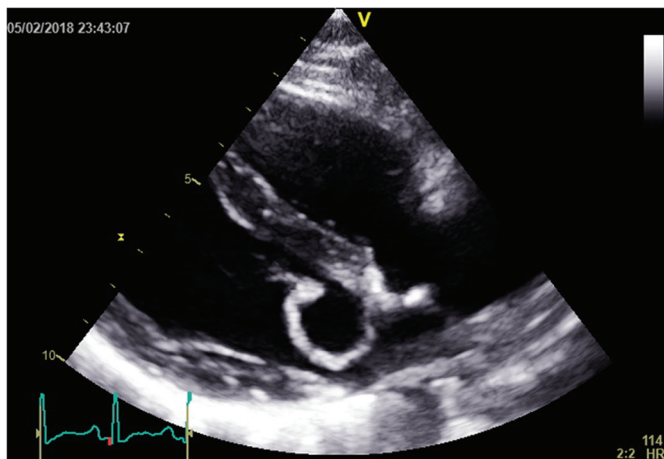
Transthoracic echocardiography: mitral valve pseudoaneurysm (long axis view).
